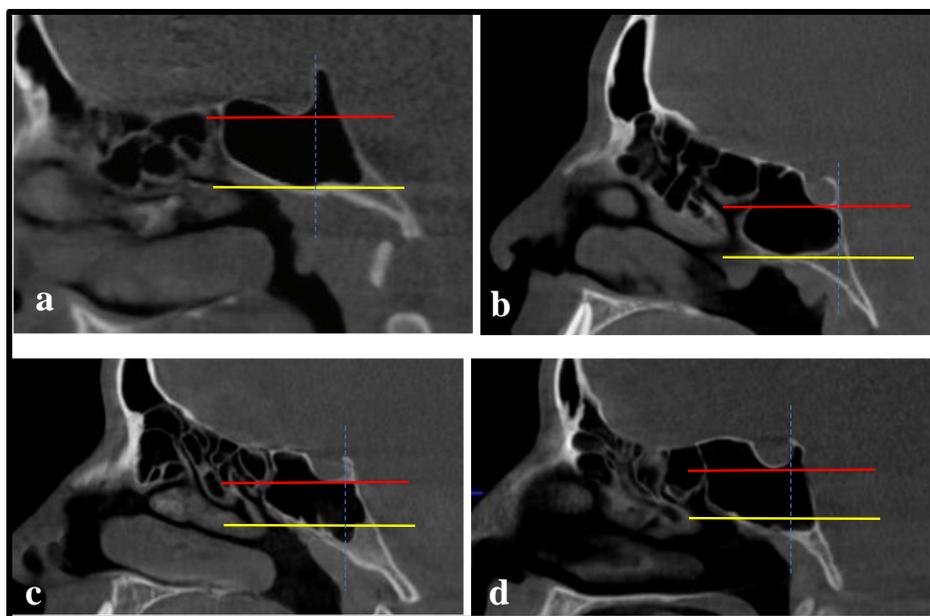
Sagittal cuts of CBCT showing pneumatization of sphenoid sinus into clivus: a) Dorsal type, b) Subdorsal, c) occipital, d) Combined type. Note: Red line: the floor of the sella and yellow line: limits of Vidian canal
